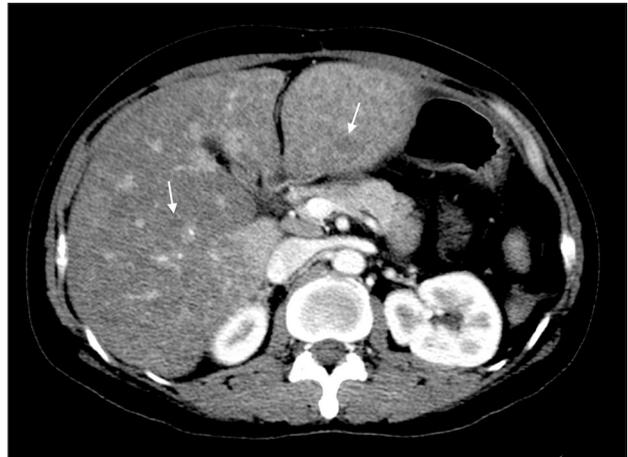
A follow-up computed tomography scan showing hepatomegaly infiltrated by multiple ill-defined nodules compatible with metastatic lesions. Some of the more discrete lesions are indicated by arrows.
